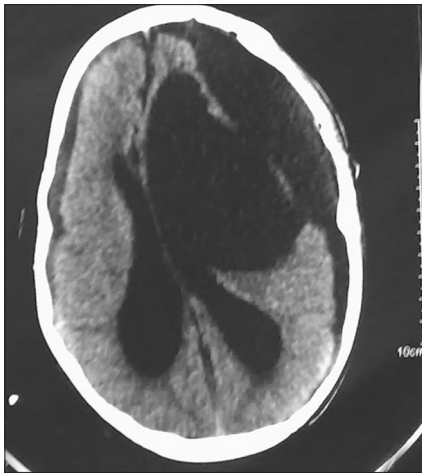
Postoperative CT scan showing subdural hygroma and operative site porencephalic cyst
